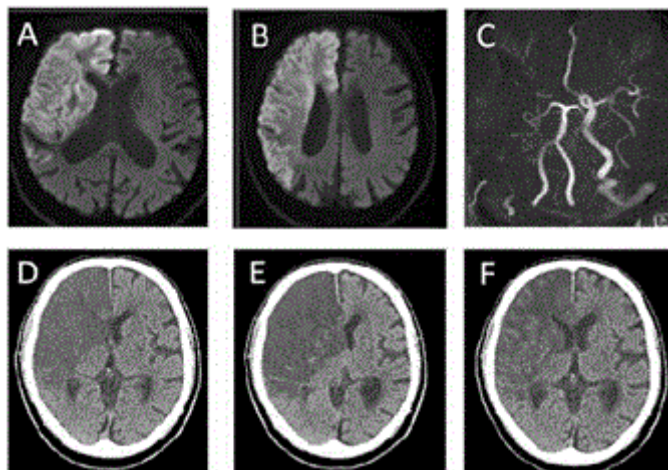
Clinical imaging of massive cerebral infarction A-C: Diffusion Weighted Image of initial MRI. Right internal carotid artery occlusion and completed infarction in anterior and middle cerebral artery territories were observed. D-F: Non-contrast CT scans taken on Day1 (D), Day3 (E), and Day14 (F). Expansion of brain edema was minimized by intravascular temperature management.
